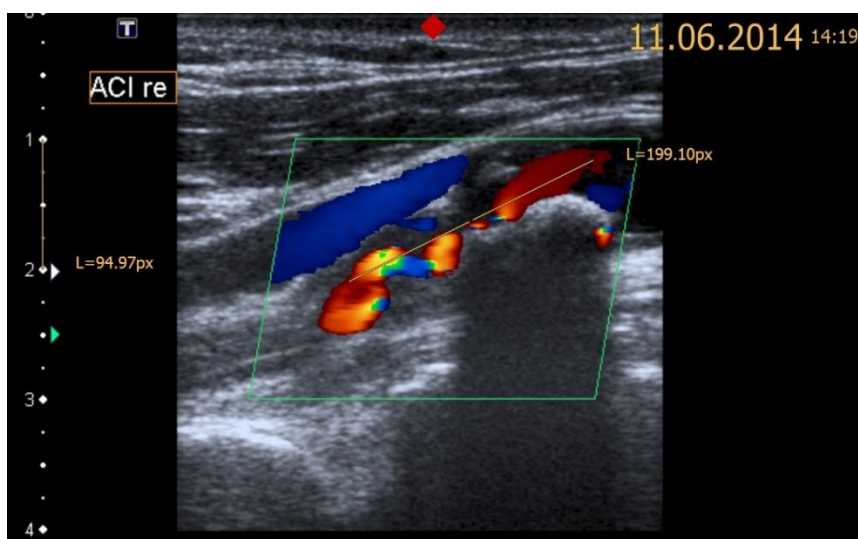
Ultrasound examination (patient 79) showing a calcified plaque with a length of 21 mm causing an ICAD of 90% on the right side
